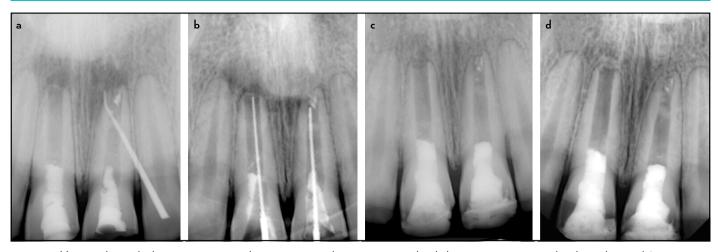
(a) PA radiograph showing a gutta-percha point tracing the sinus tract and radiolucent areas associated with tooth 11 and 21 at 6 years recall visit. (b) Radiograph for working length determination for the 2nd REP attempt. (c) Immediate post-operative radiograph. (d) 7 years recall radiograph (one year after the 2nd REP) showing resolution of periapical radiolucency with re-establishment of normal periodontal ligament space and lamina dura and apical closure
